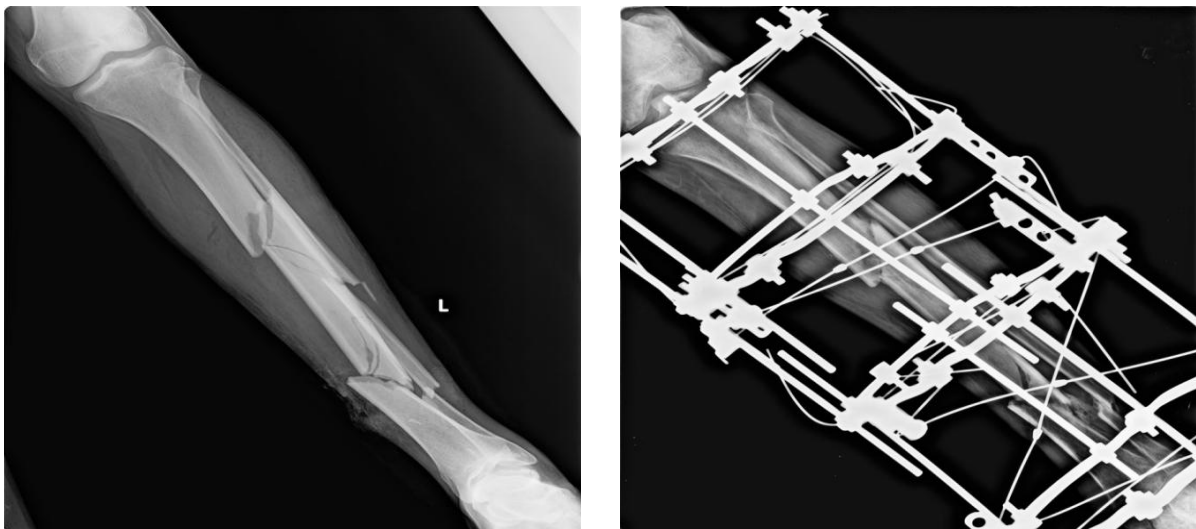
segmental tibia # pre and post operative x-rays
